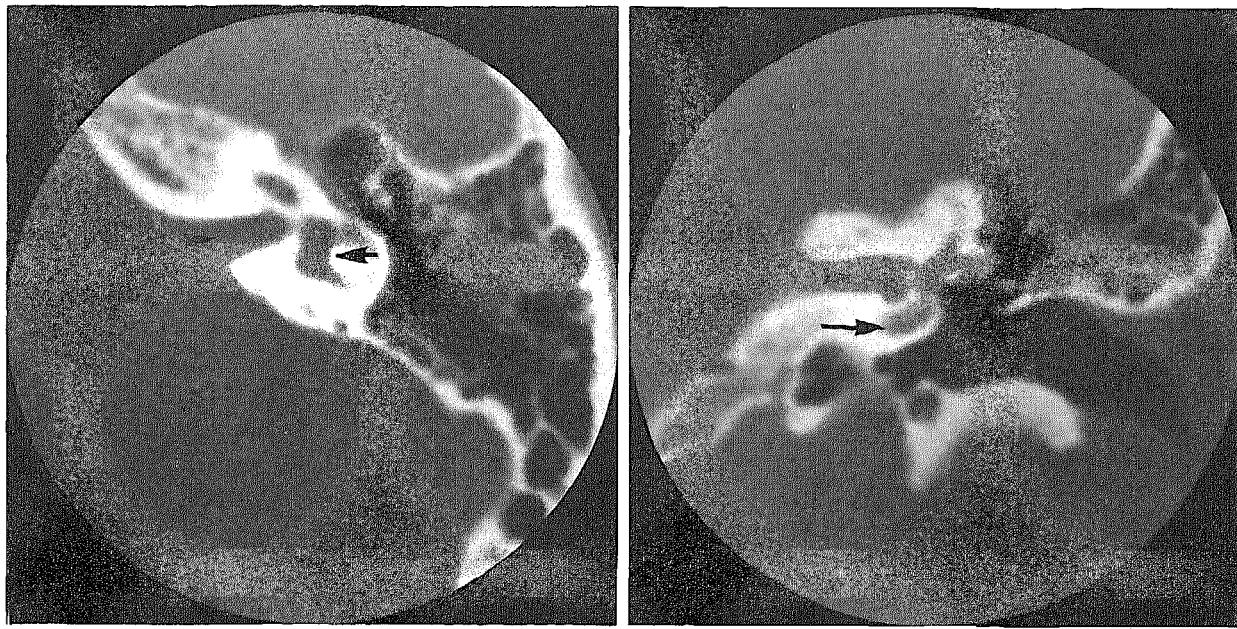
(left). Axial CT section of a normal left petrous pyramid at the level of the internal auditory canal (arrowhead). Arrow indicates vestibule.
